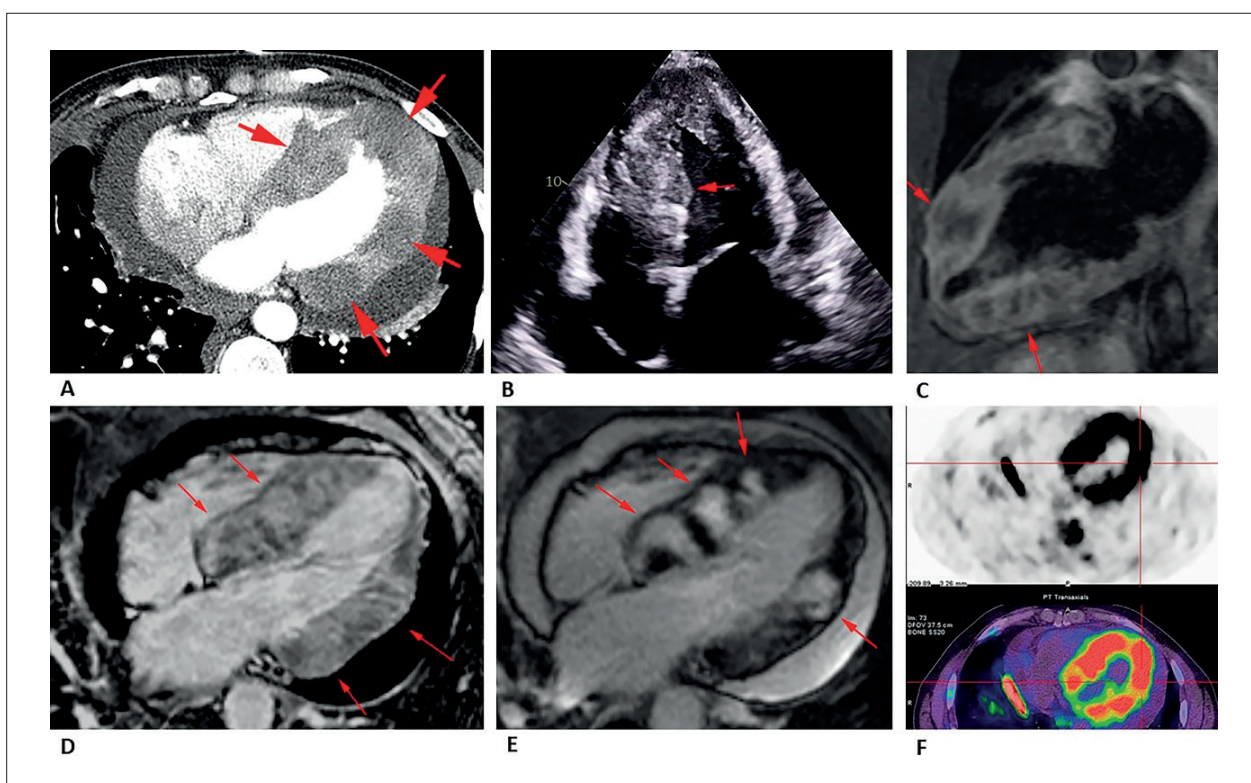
Different imaging modalities showing multiple intracardiac metastases. A) Chest CT; B) Transthoracic echocardiography; C-E) Cardiac MRI showing hypointense lesions on T2-weighted images with a peripheral halo of hyperintensity (C); early heterogeneous enhancement (D) and late intense gadolinium enhancement (E); F) abnormal uptake of fluorodeoxyglucose on 18F-FDG PET/CT.
